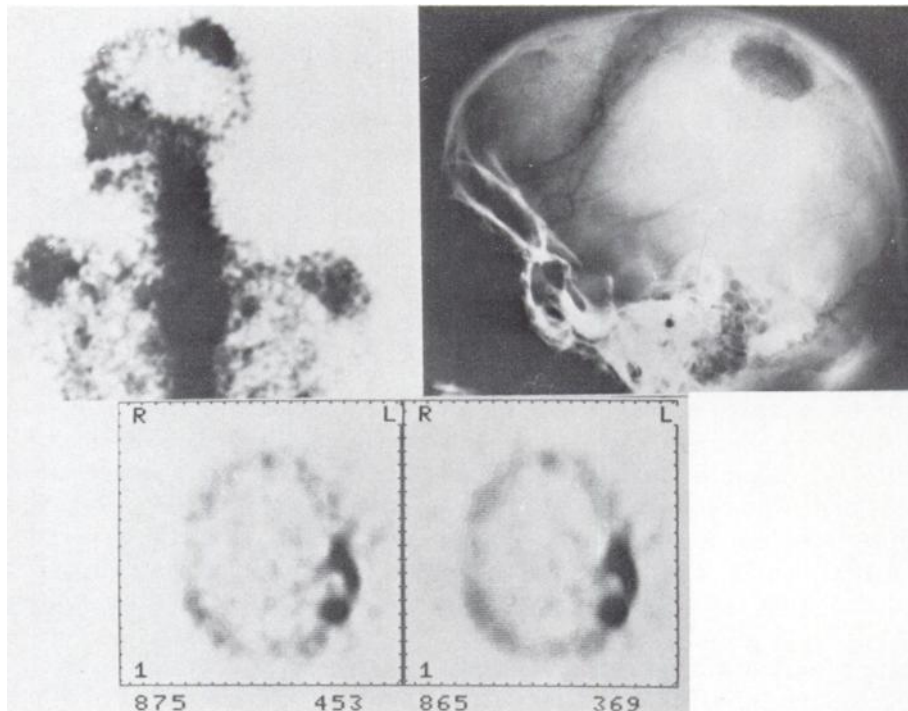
Female patient, 42 years old, with lytic bony lesions in pelvis and femur. Skull radiograph, bone scan, and emission tomography. Metabolically active lesions best displayed by emission section scanner.
